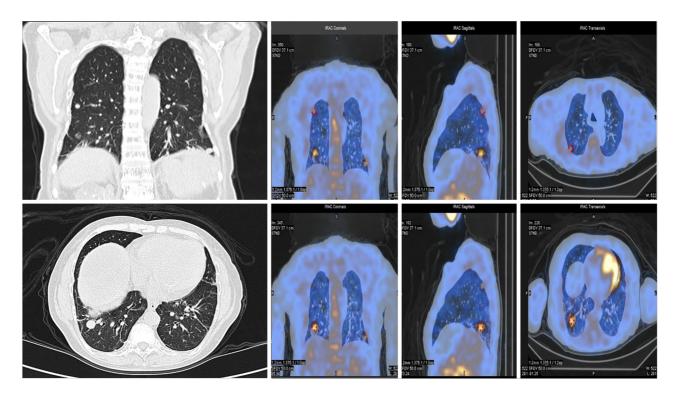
Chest computed tomography. Multiple nodules are apparent in the lung area, and 99mTc-methoxyisobutyl-isonitrile scintillation scan showed accumulation of radioactive isotopes over the lesions.
